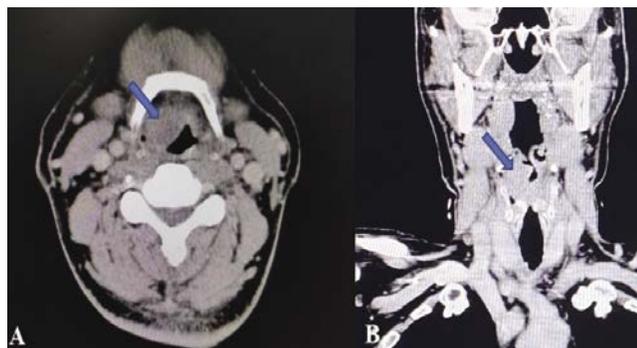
Axial view (panel A) and coronal view (panel B) of a contrast-enhanced CT of the neck of case 1 showing homogenous enhancing lesion at the right side of the epiglottis (blue arrows).
